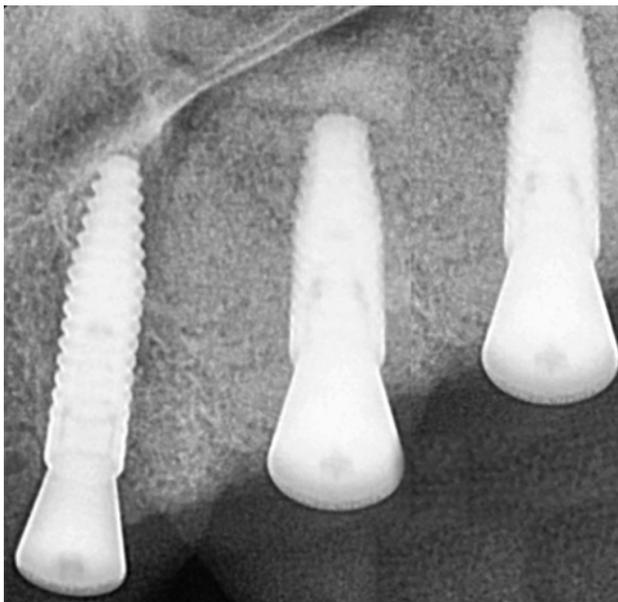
Immediate postoperative periapical radiograph of implant placement.
